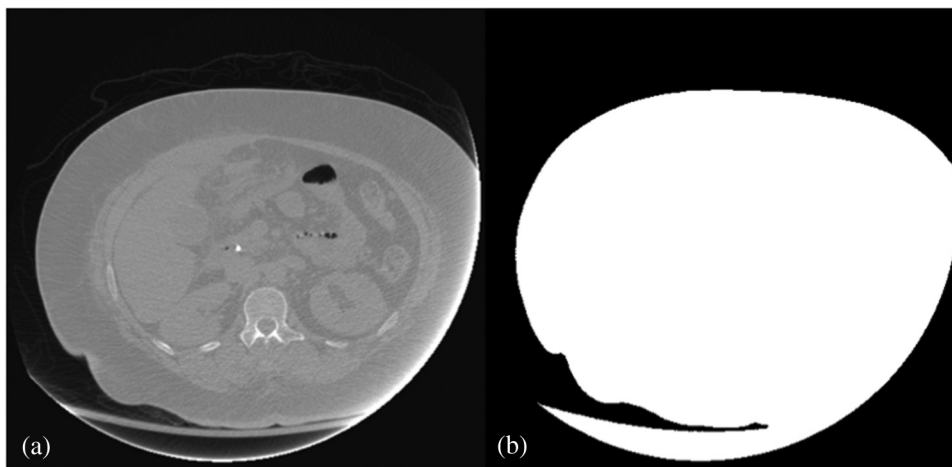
(a) Image of a patient that was improperly positioned in the bore of the CT scanner. An artifact is apparent on the right side of the image. (b) Failed segmentation of the image due the artifact.
